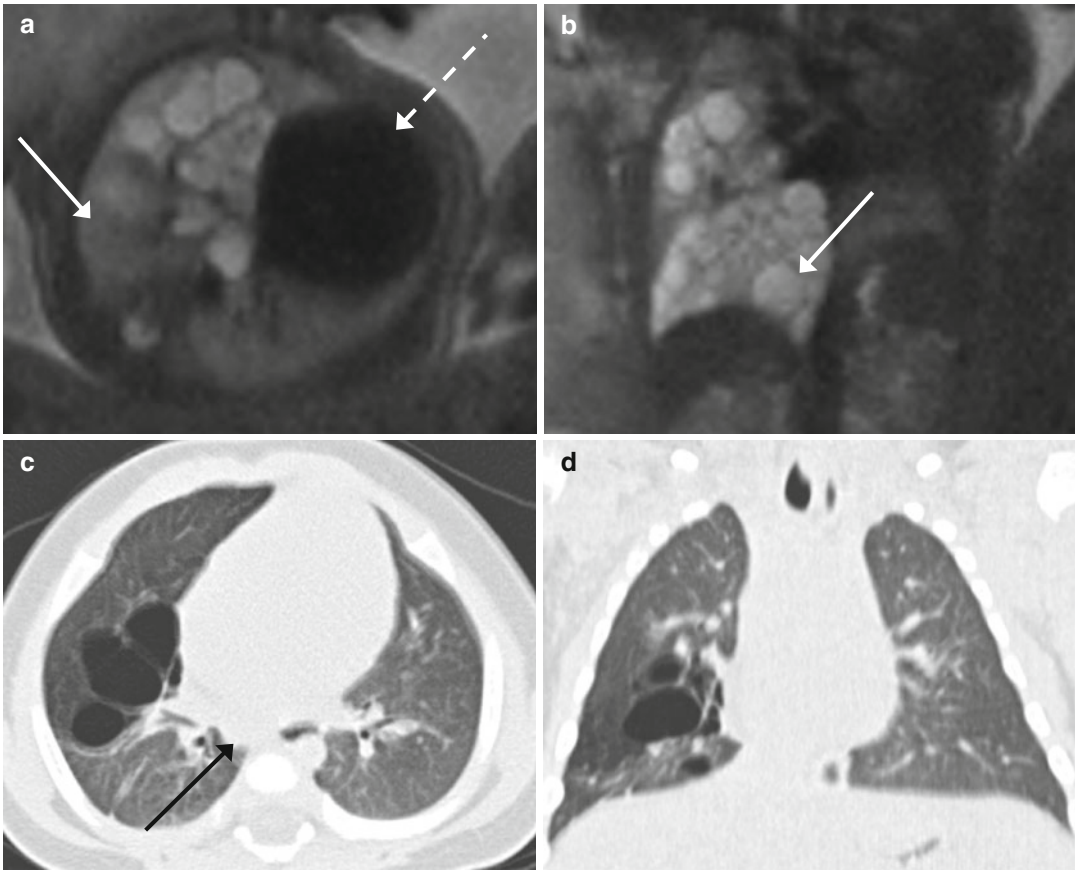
Congenital pulmonary airway malformation (CPAM) of type II (GW 26+4); the lesion was already diagnosed at the ultrasonographic (US) screening of the second trimester. (a, b) Axial (a) and coronal (b) T2-weighted images (TR/TE ∞ /95 ms): the lesion is localized in the medium and inferior right lobes, and it is characterized by many cysts of different sizes that appear
